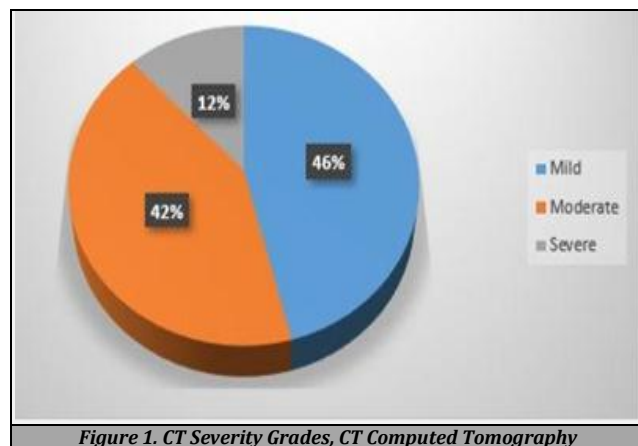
CT Severity Grades, CT Computed Tomography
